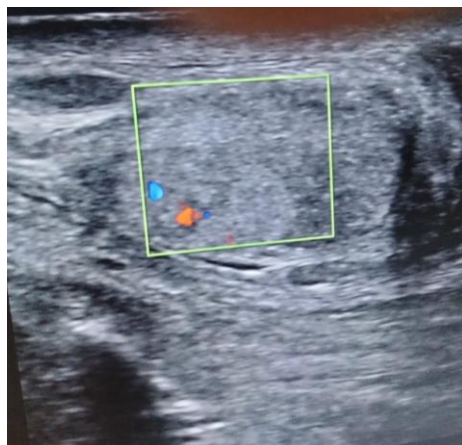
Ultrasound scrotum shows heterogeneous echotexture of testis.
